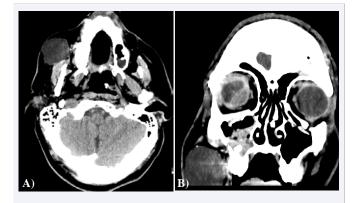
Axial and coronal soft tissue window non-contrast CT images through the parotid and sub mandibular regions. A low attenuation cystic mass lesion $(3 \times 3 \text{ cm})$ is seen anterior to the right parotid gland, extending on the surface of the mandible. The lesion's density is of fluid (9 HU). The fat planes around this abnormality are not interrupted. The adjacent gland parenchyma appears normal.
